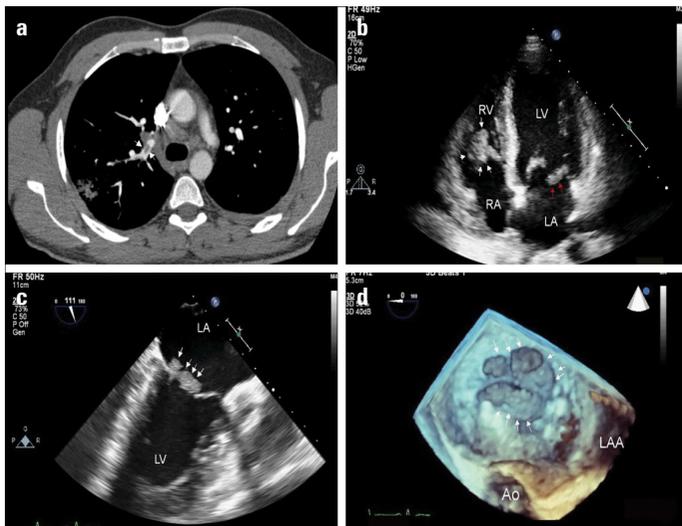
Contrast enhanced computed tomography indicates the right segmental pulmonary embolism (a) (white arrowheads). Transthoracic echocardiography shows a mobile thrombus in the right ventricle and a nonobstructive mitral valve thrombosis (b) (white and red arrowheads, respectively). Two- and three-dimensional transesophageal echocardiography demonstrate that a nonobstructive mitral valve thrombosis on the left atrial side (c, d) (white arrowheads)
